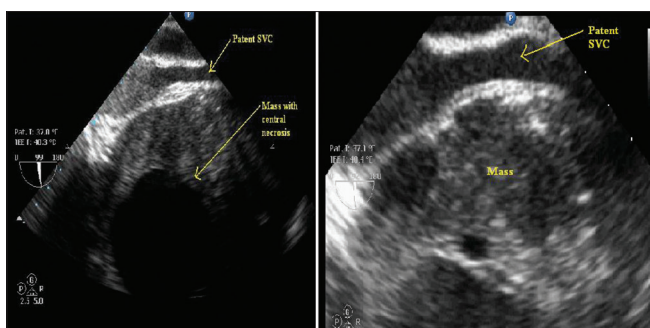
Transesophageal echocardiography image with bicaval view (zoom view-right panel) showing mediastinal mass lateral to superior vena cava but without any infiltration or compression
